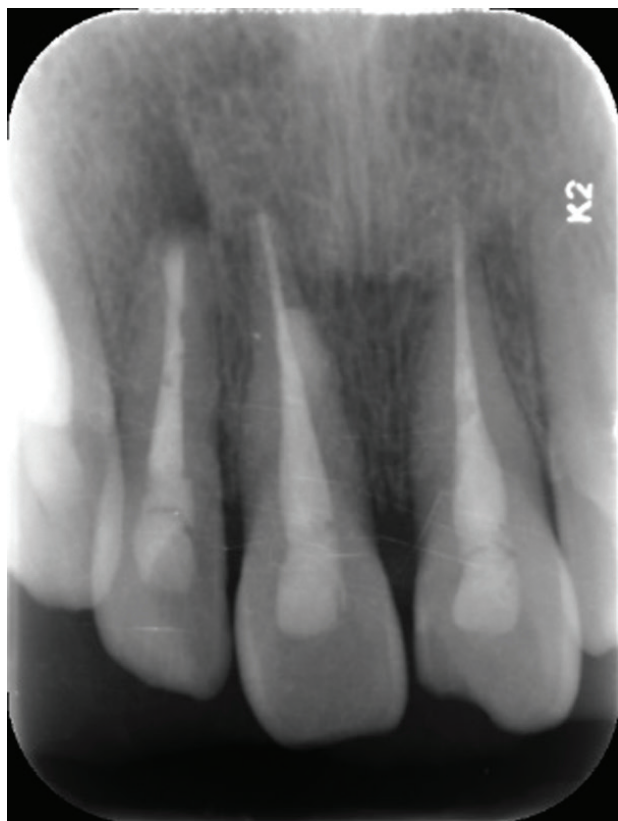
Postoperative radiograph indicating that the lesion of tooth 11 was filled, the lesion of tooth 12 was removed, and the root-end cavity was adequately filled.
